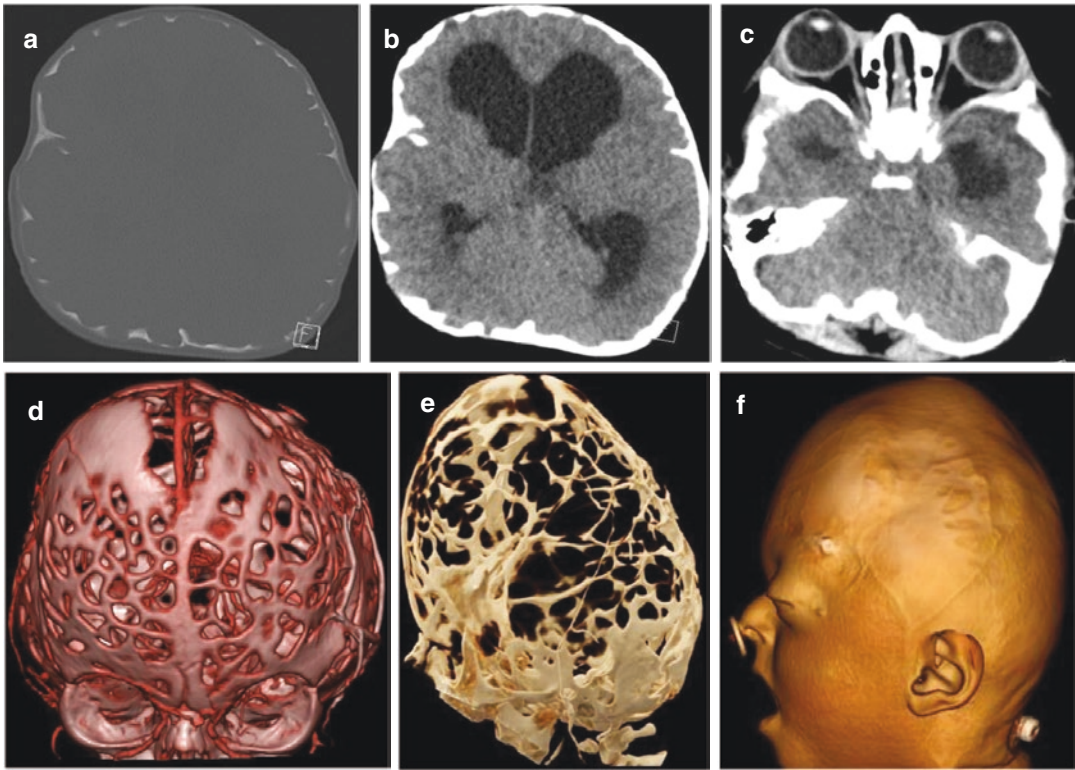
Presurgical low-dose CT of a 2-month-old boy with Crouzon syndrome reveals a “copper beaten” thinning of the calvarium (a) on axial images in bone window. Compensated hydrocephalus, elapsed external cerebrospinal fluid spaces (b), and orbital proptosis (c) shown on axial CT images in brain window are consequences of craniosynostosis and chronically increased intracranial pressure. 3D volume rendering technique (VRT) images
